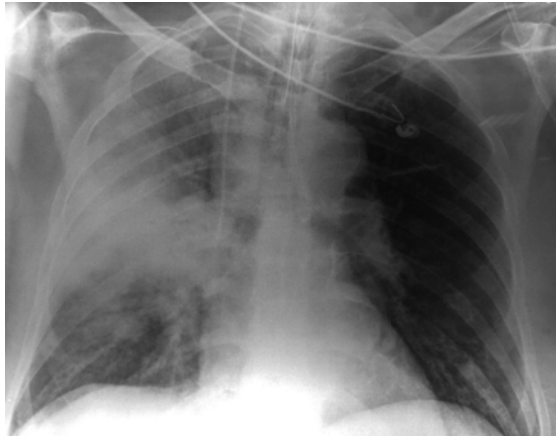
Portable chest X-ray on the second day revealed increased infiltration.
